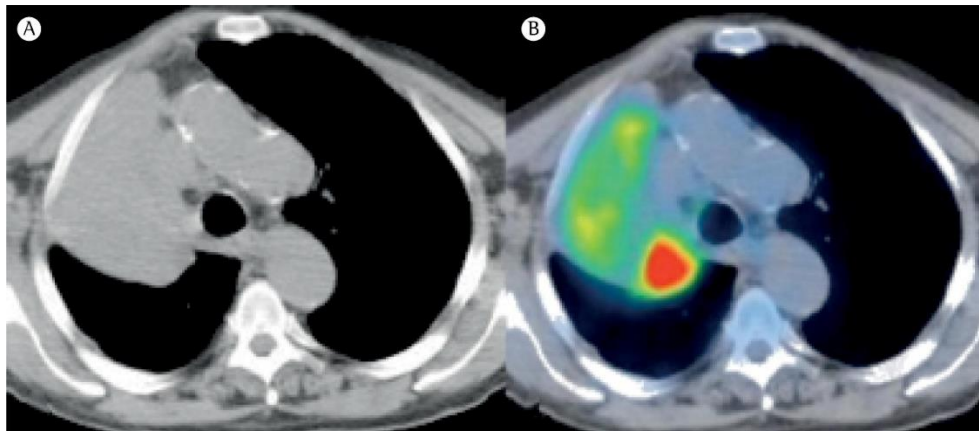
PET/CT images showing the difference between normal surrounding tissue and tumour with active cancer cells coloured. (a) CT image (b) PET/CT image (Hochhegger et al., 2015)
